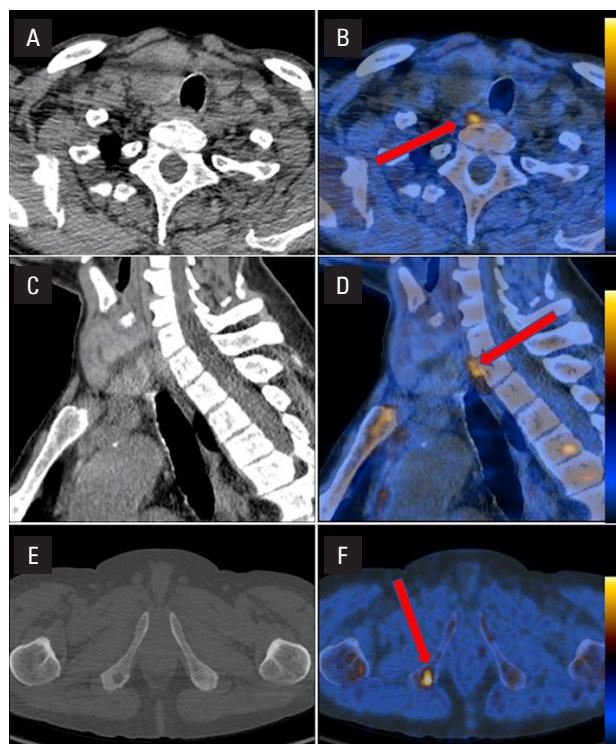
Images (B, F — transaxial and D — sagittal fused 18 -choline positron emission tomography/computed tomography (PET/CT); A, E — transaxial and c-sagittal axial CT) of a 61-year-old patient with primary hyperparathyroidism. Fused scans (B, D) show a choline-avid focus (parathyroid adenoma) between the right thyroid lobe and C6–C7 vertebral bodies. Neck ultrasound and scintigraphy were negative. The adenoma was successfully excised after ^{18}F -FCH PET/CT. PET/CT also showed a brown tumour of the right ischium (F — transaxial fused PET/CT scan; E — transaxial CT scan)
